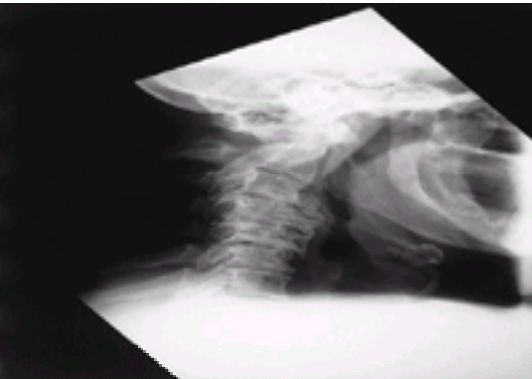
Lateral cervical radiograph showing severe cervical spondylosis. However, this patient had no symptoms relating to this. Hence the importance of a clinical assessment by taking a history and examining the patient. The cervical spine has a very low range of movement on flexion–extension, which is probably why no neurological complications developed.
